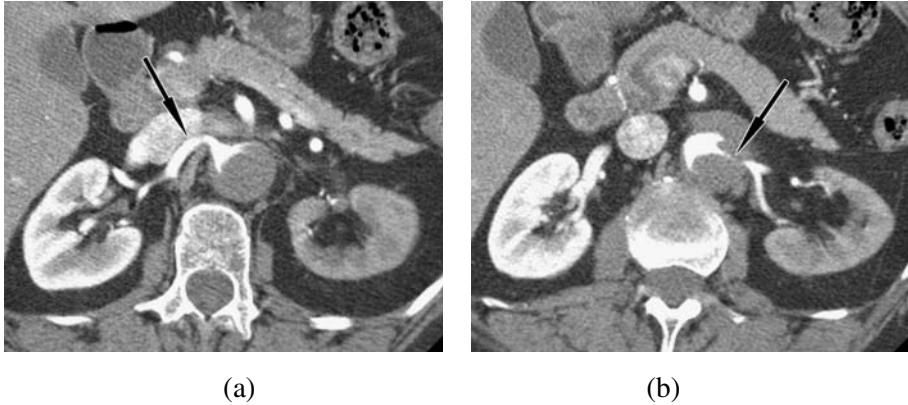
Axial contrast-enhanced CT images of a thrombosed false lumen (intramural hematoma), which compresses the true lumen at the level of the renal artery origins: (a) perfusion of the right renal artery (arrow) from the true lumen is maintained; (b) left renal artery origin is compressed (arrow), (note delayed enhancement of the left kidney consistent with impaired perfusion).
